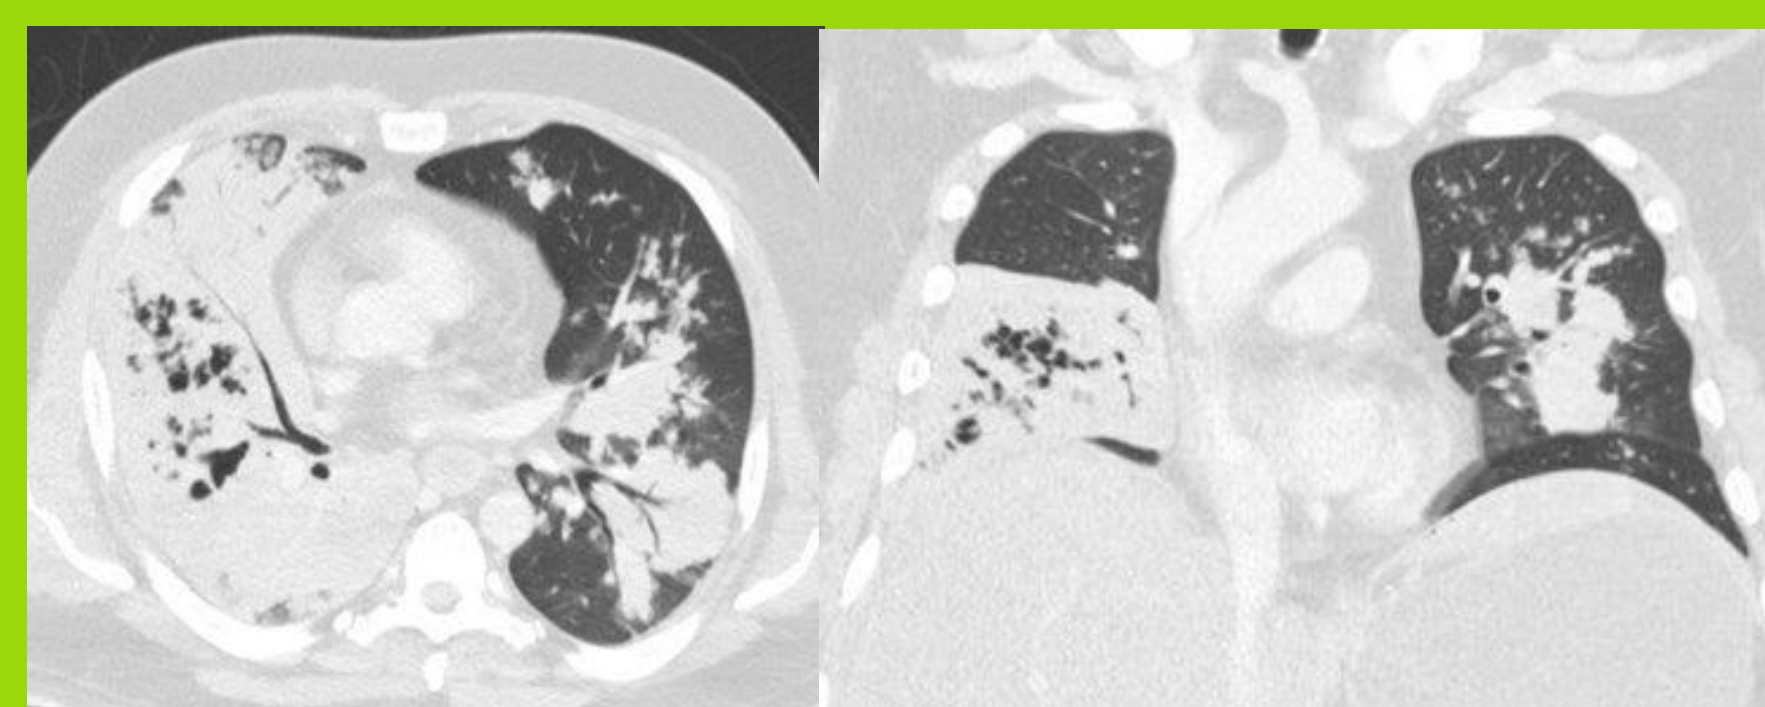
Multifocal consolidation in chest CT.
